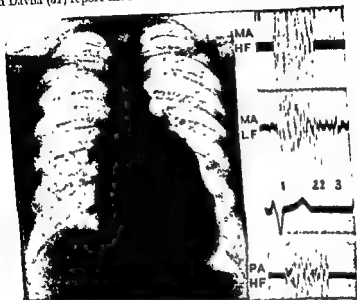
Mitral incompetence X-ray shows unusually large
